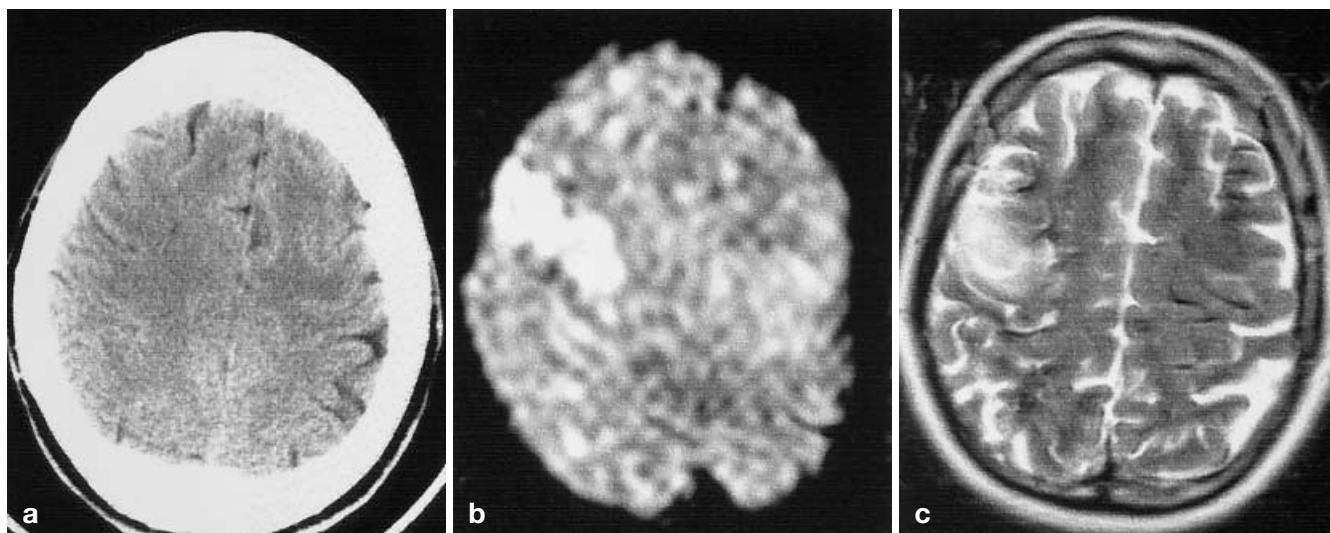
As Fig. 1. A 54-year-old patient first examined 3 h after the onset of a left hemiparesis. DWI shows cortical high signal, but CT is normal. Five days after the ictus the T2-weighted image shows the cortical infarct
